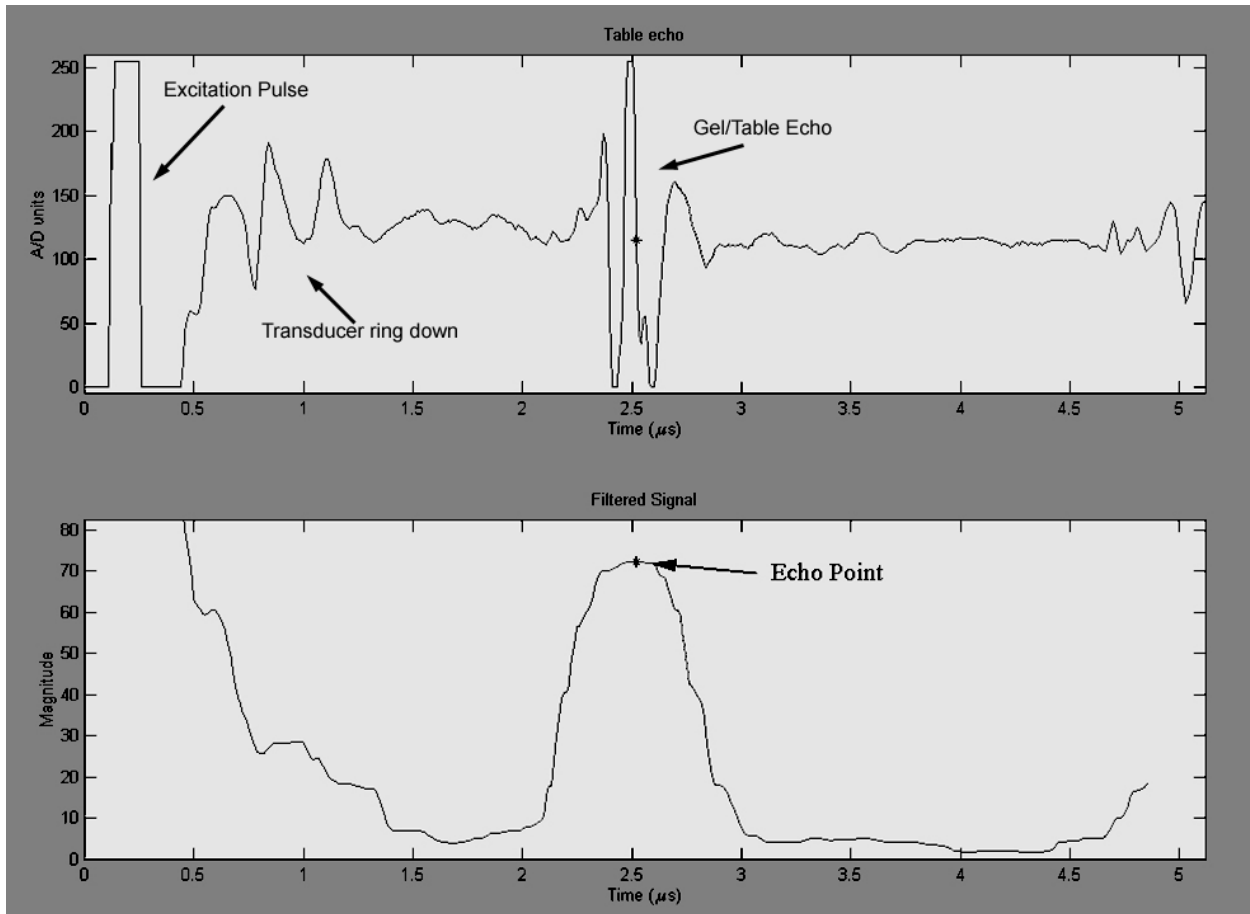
Sample ultrasound signal with a table echo (top) and windowed standard deviation filter output (bottom). Features visible in the ultrasound signal include the excitation pulse generated by the multiscanner, the transducer recovery or ring down period, and the echo arising from the transmission gel/table interface.
